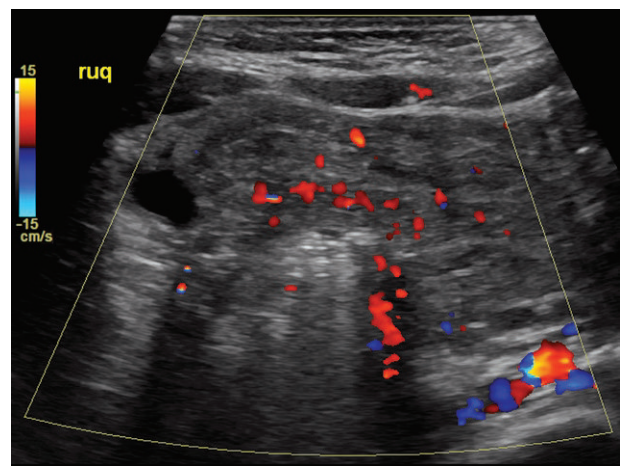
Color Doppler demonstrates flow in the bowel in this case of intussusceptions.
